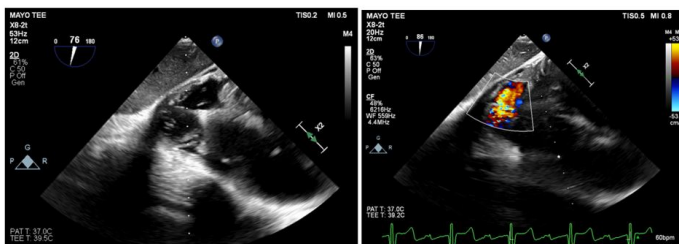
Intraoperative transesophageal echocardiogram showed LV apical pseudoaneurysm and an apical VSD with a left-to-right shunt on color Doppler.
